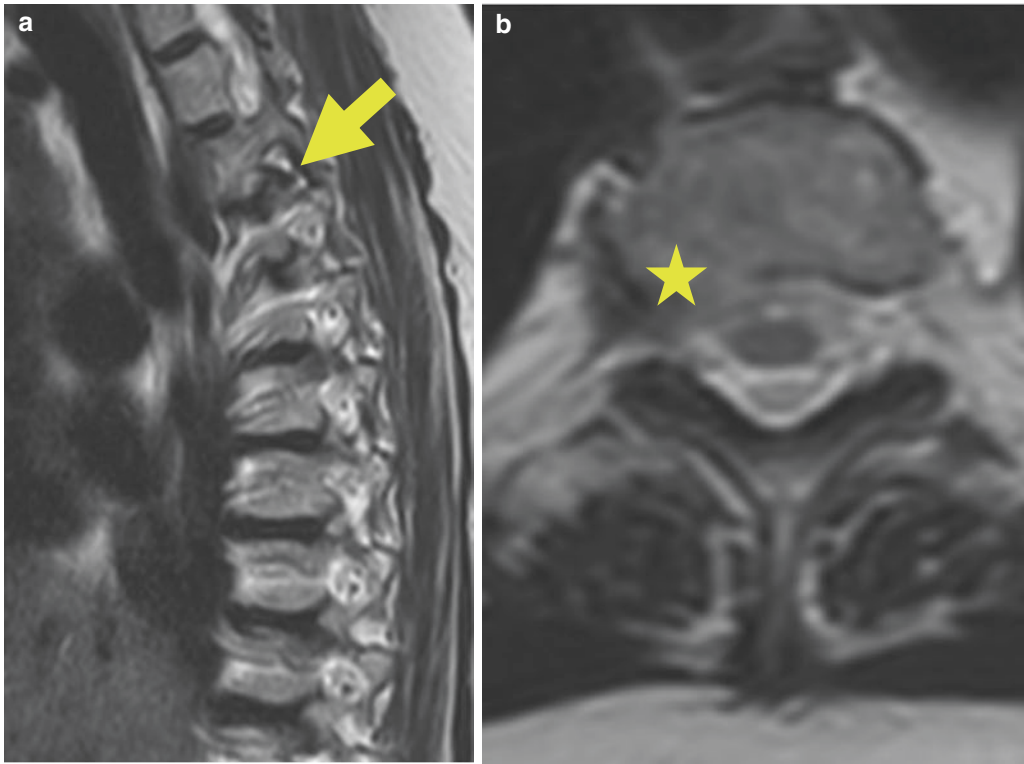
Sagittal (a) and axial (b) T2-weighted imaging of the thoracic spine demonstrates a right foraminal disk protrusion (star) causing moderate right neural foraminal stenosis
